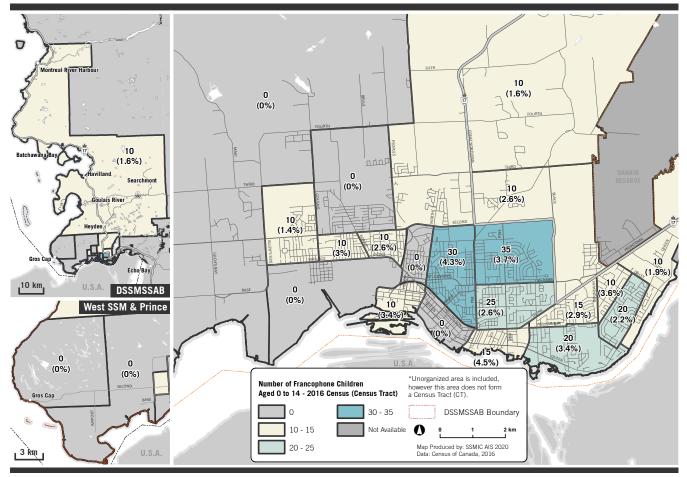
Francophone Children Aged 0 to 14 by Census Tract (CT), DSSMSSAB Area, 2016
